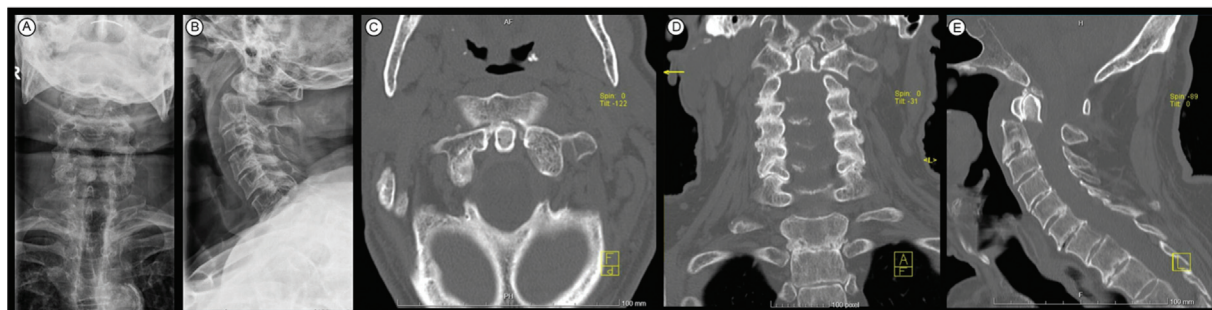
Radiograph and CT scan of the cervical spine - fracture-dislocation of the odontoid apophysis – AP (A) and lateral incidences (B), on the axial (C), coronal (D), and sagittal planes (E).
